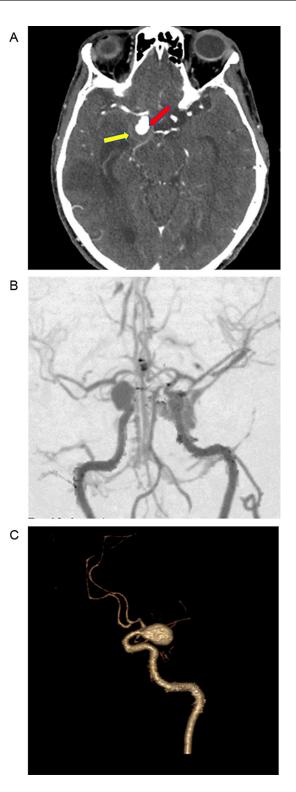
Axial section of cerebral CT scan in the parenchymal window after injection of contrast medium (A), and in multiplanar reconstructions (B and C), showing a saccular dilatation of the supra-clinoid portion of the right internal carotid artery (red arrow), with a hypodense peripheral collar (yellow arrow), related to a ruptured and partially thrombosed aneurysm of the internal carotid artery (Color version of figure is available online) cranial nerves or the surrounding cerebral parenchyma (50% of cases).
